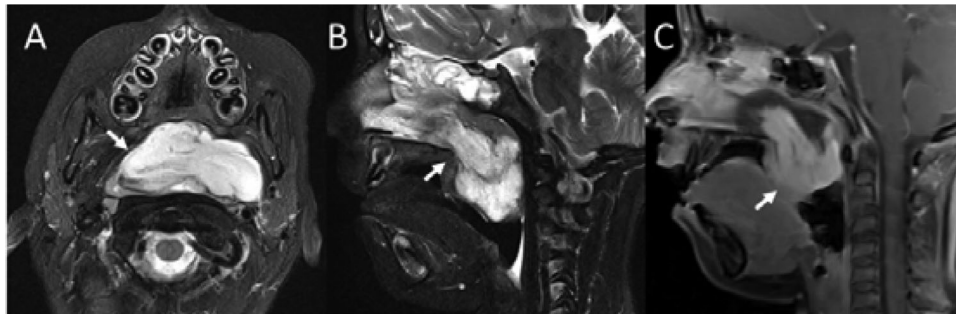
Axial fat-suppressed T2-weighted (A), sagittal fat-suppressed T2-weighted (B), and sagittal contrast-enhanced fat-suppressed T1-weighted (C) MR images of a child with a rhabdomyosarcoma. The axial image (A) shows a large T2 hyperintense mass primary arising from the oropharynx. The surrounding cervical spaces are predominantly displaced by the mass. The sagittal T2-weighted image (B) demonstrates the extension into the nasopharynx and ethmoid sinus. Bony involvement is seen. On the contrast-enhanced image (C), relative homogenous enhancement of the lesion with some areas of focal necrosis is seen.
